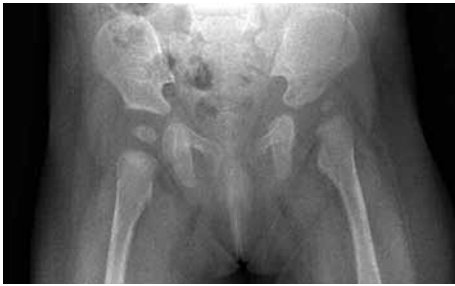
Case 1. Radiographs confirming subluxation of the left hip in the upper outer quadrant with an acetabular index of 31° on the left and 25° on the right.
